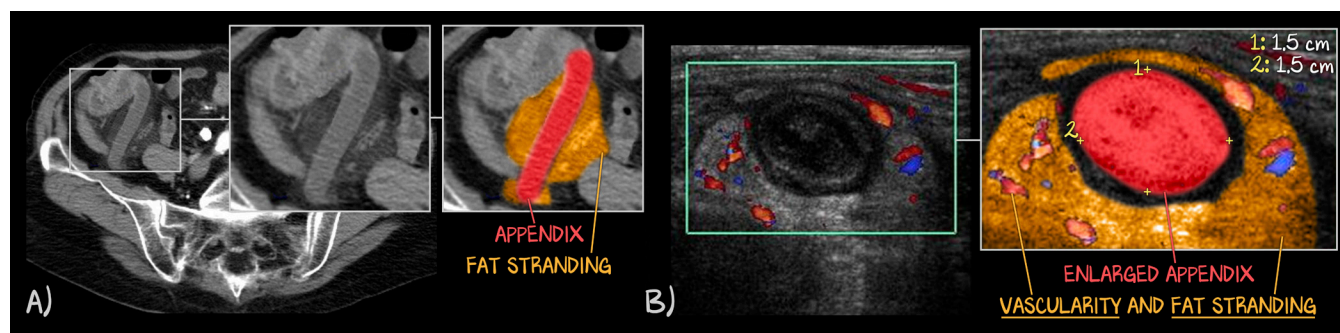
Radiographical Appendicitis
